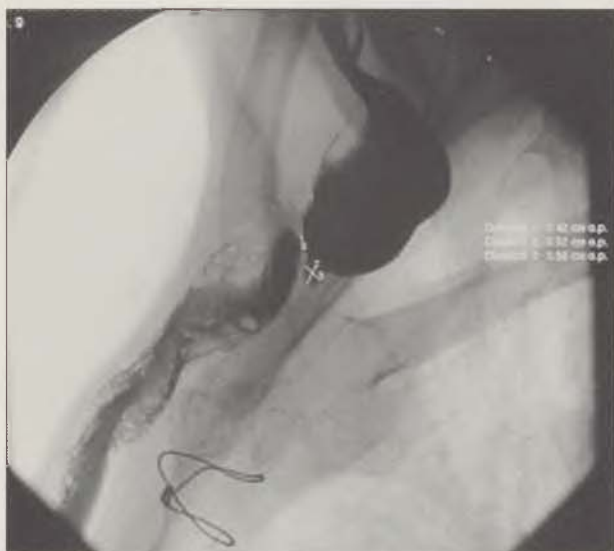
Contrast X-ray examination demonstrating deteriorated patency at the site of upper anastomosis caused by bending
